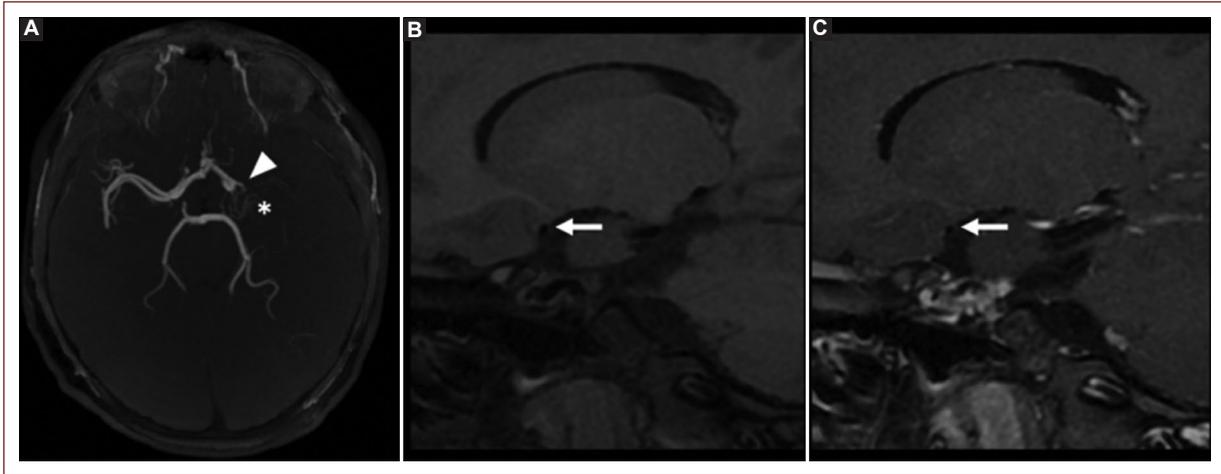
Magnetic resonance imaging. A: axial 3D time of flight maximum intensity projection image shows flow signal absence in the M1 segment of the left cerebral media artery (white arrowhead), associated with fine vessels forming a rete mirabilis (white asterisk). Three-dimensional (3D) variable-flip-angle turbo-spin-echo (CUBE) T1-weighted sequence with fat suppression, before (B) and after gadolinium administration (C), shows no enhancement of the left cerebral media artery wall (white arrow).
